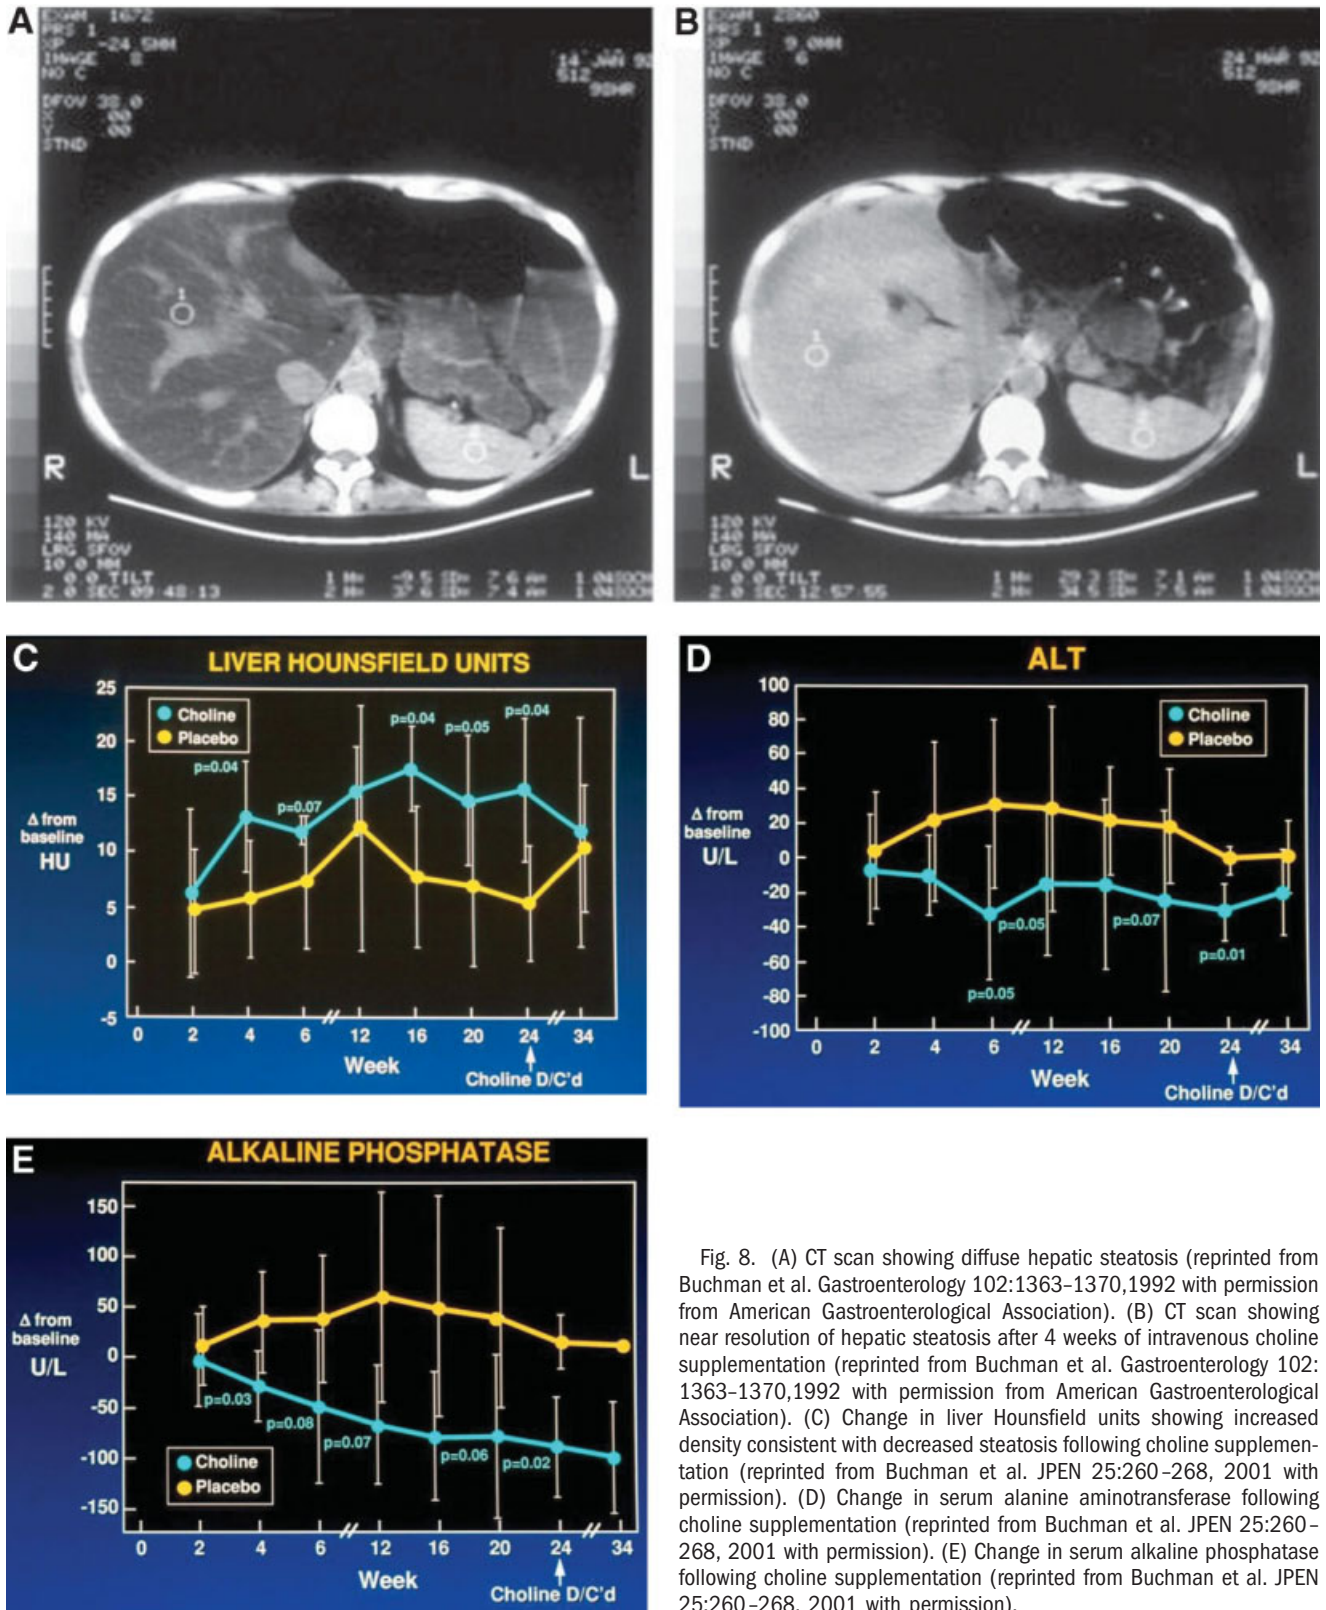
(A) CT scan showing diffuse hepatic steatosis (reprinted from Buchman et al. *Gastroenterology* 102:1363-1370,1992 with permission from American Gastroenterological Association). (B) CT scan showing near resolution of hepatic steatosis after 4 weeks of intravenous choline supplementation (reprinted from Buchman et al. *Gastroenterology* 102: 1363-1370,1992 with permission from American Gastroenterological Association). (C) Change in liver Hounsfield units showing increased density consistent with decreased steatosis following choline supplementation (reprinted from Buchman et al. *JPEN* 25:260-268, 2001 with permission). (D) Change in serum alanine aminotransferase following choline supplementation (reprinted from Buchman et al. *JPEN* 25:260-268, 2001 with permission). (E) Change in serum alkaline phosphatase following choline supplementation (reprinted from Buchman et al. *JPEN* 25:260-268, 2001 with permission).
